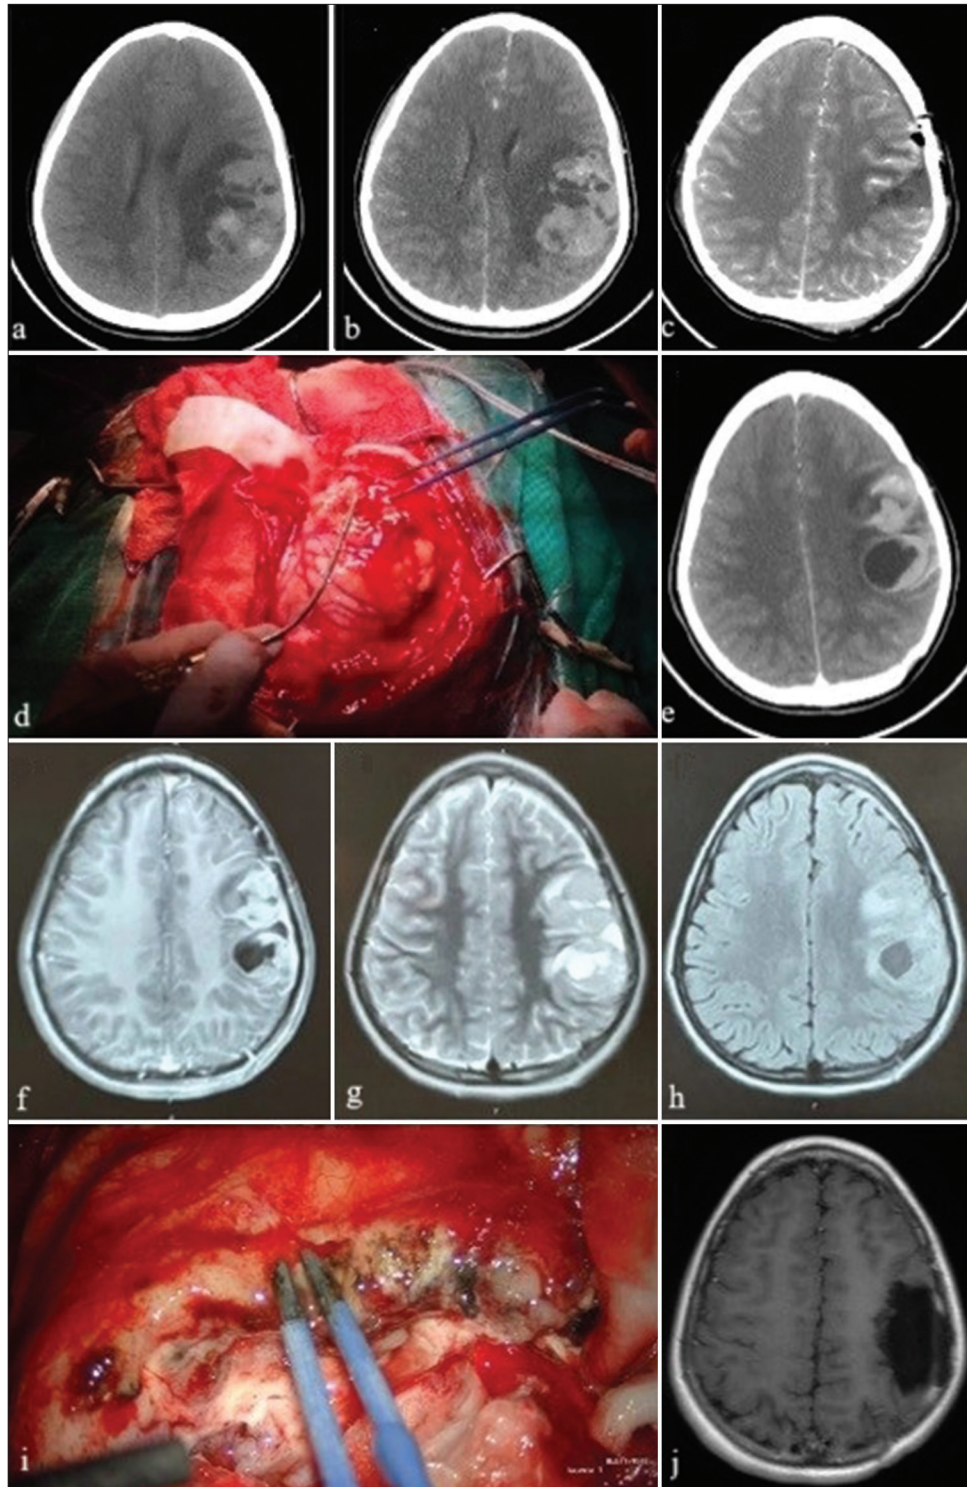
Brain scans and intraoperative images of Case 1. (a and b) Computerized tomography (CT) scans of left frontoparietal hemorrhagic tumor with mild midline shift; (c) postoperative CT scan confirms gross total resection; (d) exposed tumor during first surgery; (e) hyperintense lesions at site of initial surgery suggestive of recurrence 1 month after first surgery; (f-h) magnetic resonance imaging (MRI) scan of recurrent lesions at surgical site; (i) fluorescein-guided resection of recurrent lesions during second surgery; and (j) postoperative MRI confirms successful resection of recurrent lesions.
